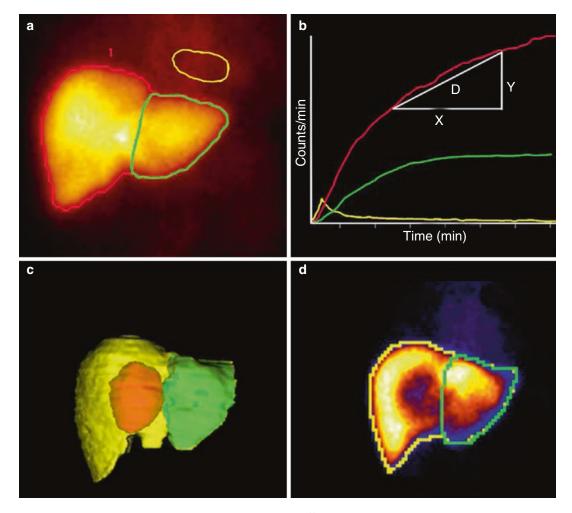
HIDA scan 150-300 seconds after i.v. injection of 99m Tc-mebrofenin (a) reveiling a blood pool corrected liver-uptake time-activity curve (b) of the whole liver and the FLR (*green*). Three-dimensional reconstructed CT images (c) are used to guide identification of the FLR on HIDA scan (d)
